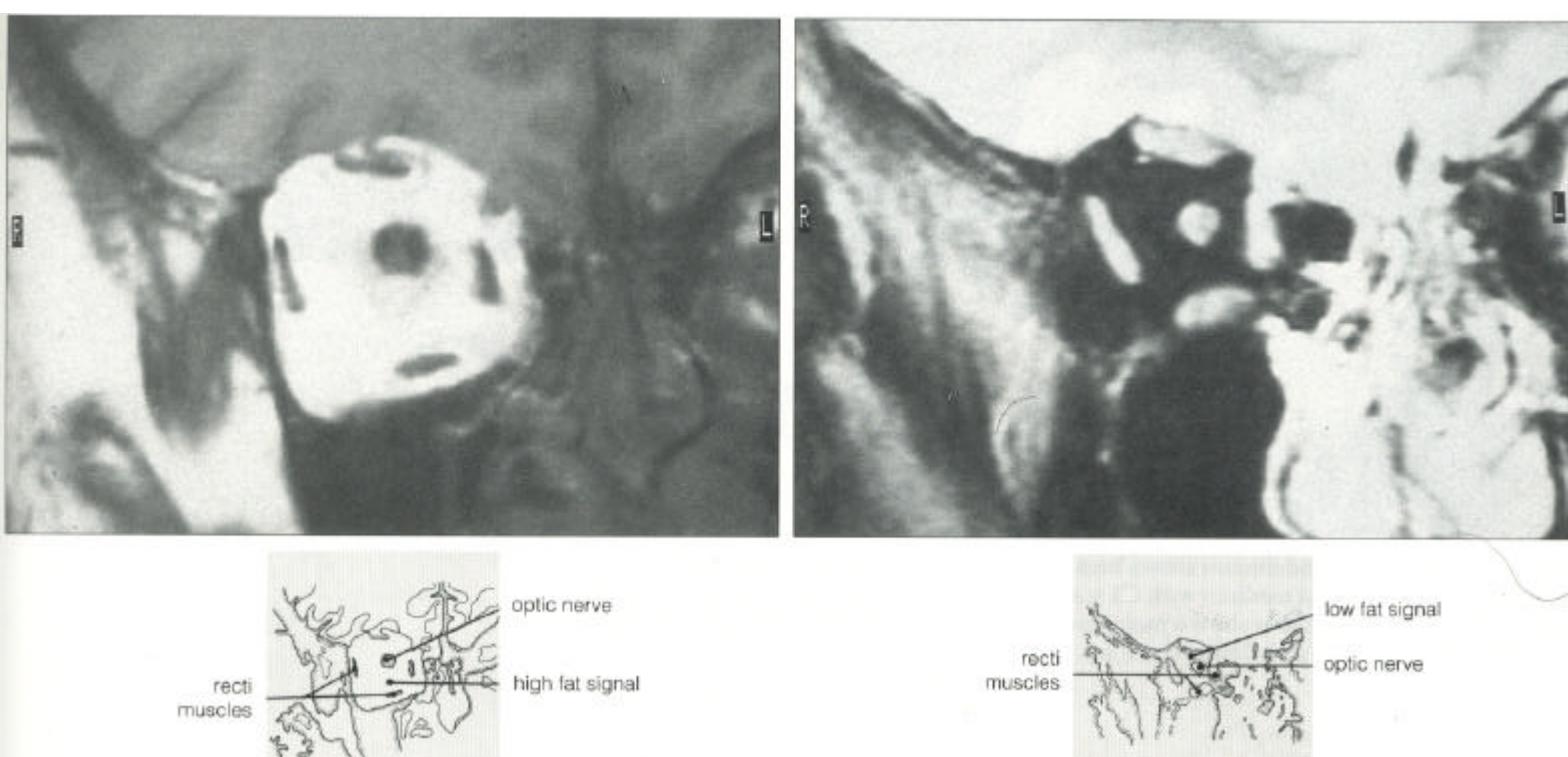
Excellent orbital views can be obtained with MRI by using surface coils but this is time consuming and requires a cooperative patient. With conventional sequences the orbital fat produces a high signal which masks the optic nerve (left). Specialized fat suppression techniques allow the optic nerve to be visualized and this has proven to be of exceptional value in the investigation of optic nerve disease (right) (see Chapter 17).
